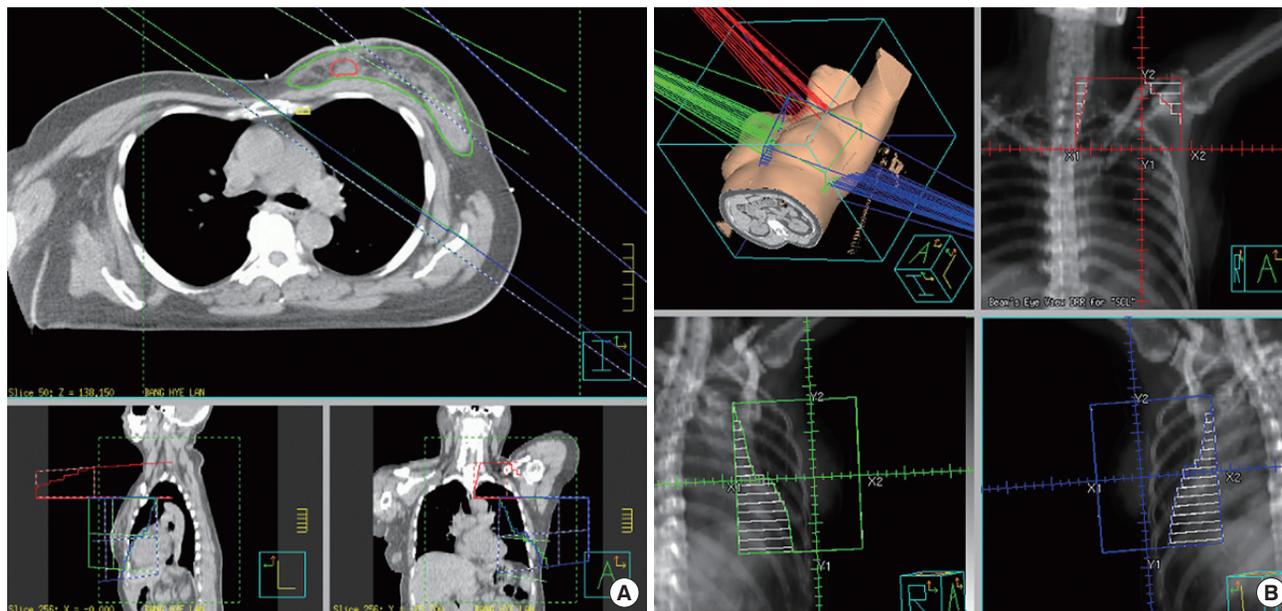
Field arrangement of partially wide tangent technique for treating supraclavicular lymph node (SCL), breast, and internal mammary lymph node (IMN). (A) Planning computed tomography image. (B) Beams-eye-view of frontal field for SCL and lateral tangential fields for breast and IMN.
